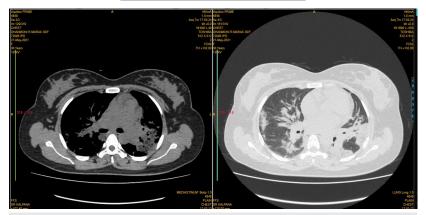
CT Scan Thorax of the Case 1 Showing Bilateral Multilobar Ground Glass Opacities
